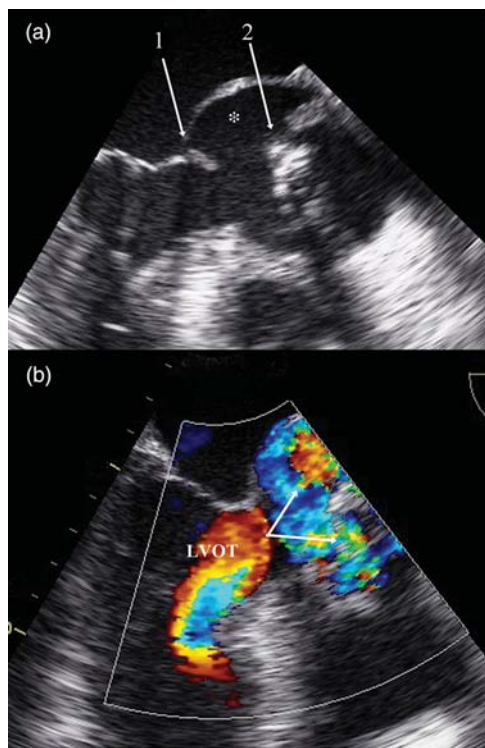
(a) The mid-oesophageal aortic valve long-axis view demonstrating the total separation of the mechanical valved conduit (arrow 2) from the left ventricular outflow tract (arrow 1). The asterisk locates the paravalvular abscess. (b) Transoesophageal echocardiographic image showing the divergence of blood flow through the abscess and the mechanical conduit (arrows). LVOT: left ventricular outflow tract.
